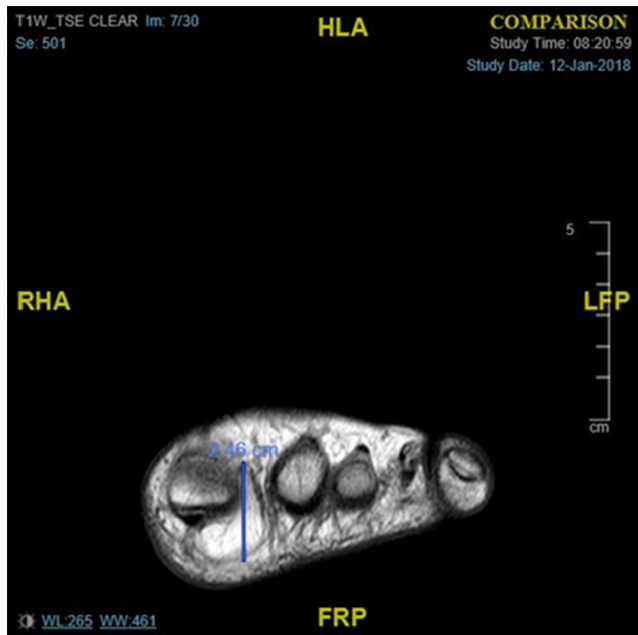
Pre-operative MRI images
